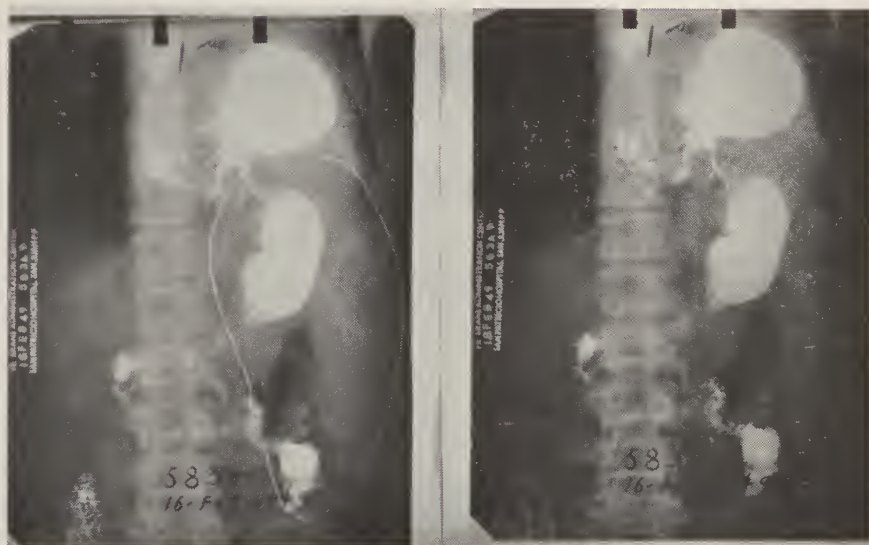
Case I. Roentgenograms demonstrating the size of the spleen before the operation. At autopsy the spleen was found greatly reduced in size, weighing 400 gms.
